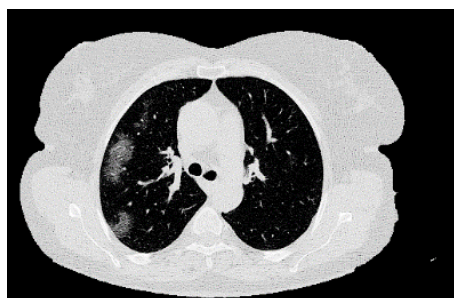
Experimental results of the proposed algorithm on a chest CT image; (a) Original Image; (b) Binary Mask of Lung Region; (c) Bronchioles & Vessel Segmentation using Frangi vessel segmentation; (d) Segmented Image with noise; (e) Binary mask ; (f) Final segmented Image
